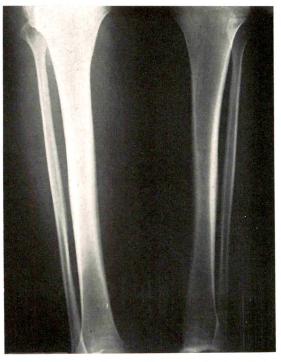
Roentgenogram of the legs showing an increase in the size of the tibia and fibula due to cortical thickening accounting for the increase in bone density.
